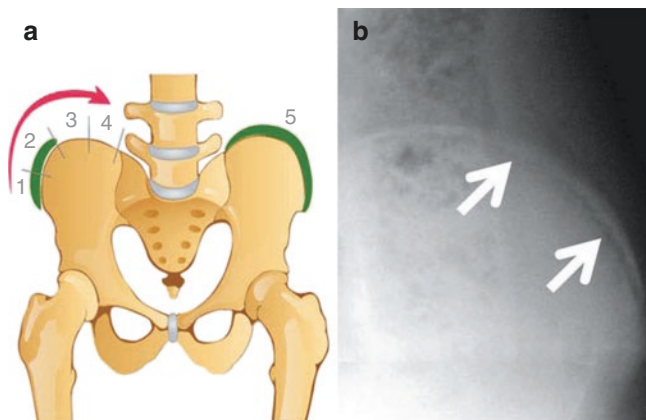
Risser sign. Fusion of the iliac apophysis proceeds from lateral to medial. Complete fusion indicates Risser stage 5. Radiograph shows Risser stage 4 (the apophysis is ossified from medial to lateral but still not fused with the iliac bone; arrows point to the open growth plate)
